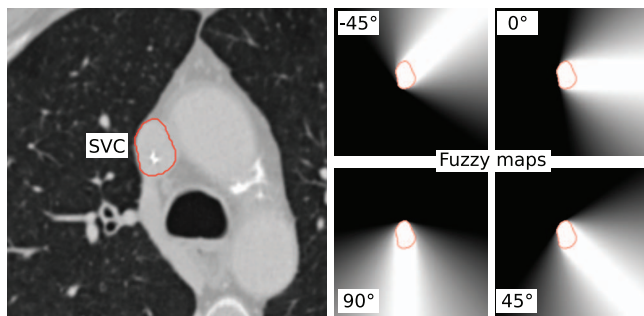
Left: CT slice with the contour of the Superior Vena Cava (SVC). Right: Examples of four fuzzy maps computed from the SVC binary image for four different α values (-45° , 0° , 45° , 90°).
